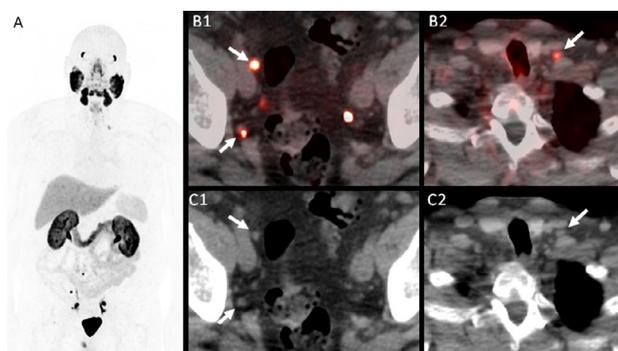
¹⁸F-DCFPyL PET/CT in a patient with biochemical recurrence PCa. A 67-year-old man with history of PCa, Gleason 8 (5 + 4), status post-prostatectomy and salvage radiation 6 years ago, with rising PSA (4.8 ng/mL). Maximal intensity projection (A), axial ¹⁸F-DCFPyL fused PET/CT (B), and low-dose CT (C) images demonstrate small subcentimeter pelvic nodes (B1 and C1) and a small left supraclavicular node (B2 and C2). Physiologic urinary uptake is noted in the bilateral distal ureters.
